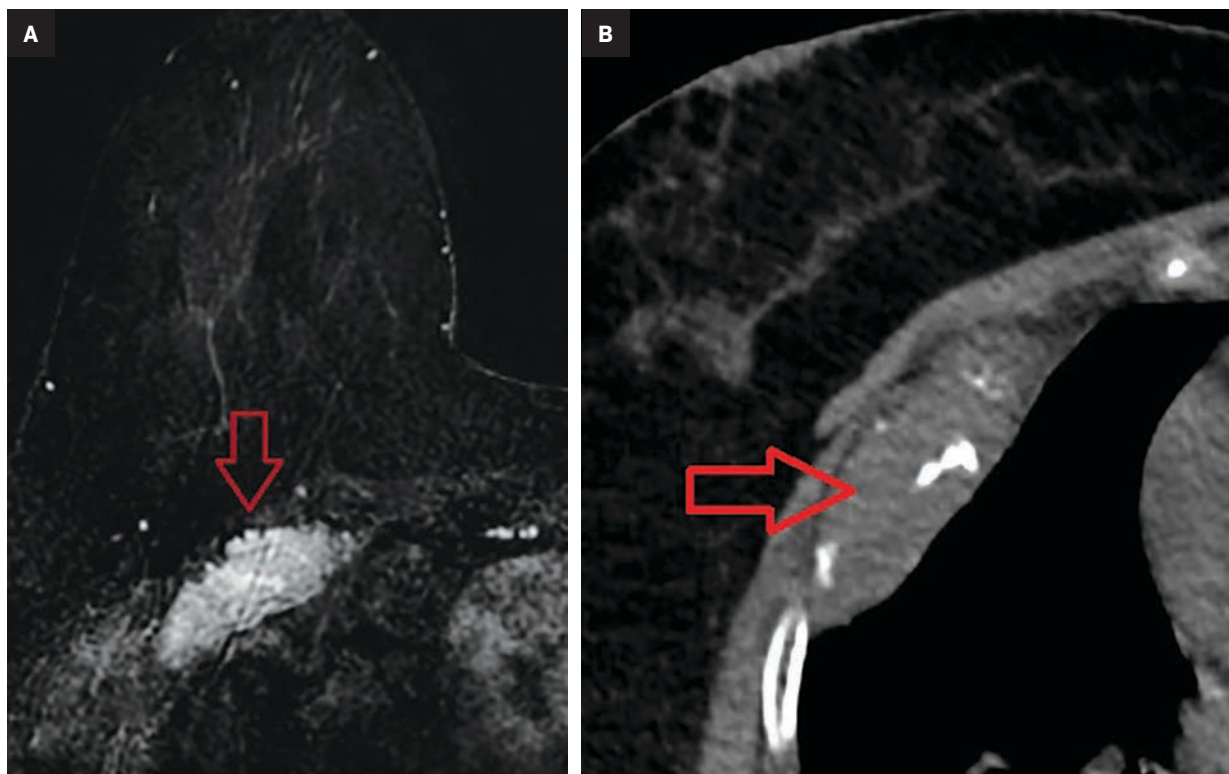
(A) T1 postcontrast subtracted image of the right breast in a patient with multiple myeloma showing an expansile, avidly enhancing, right anterior rib mass. Note the similar imaging features on MRI between multiple myeloma and other osseous metastases depicted in Figure 10. (B) Axial CT scan through the lesion shows the degree of associated osseous destruction (arrow).
